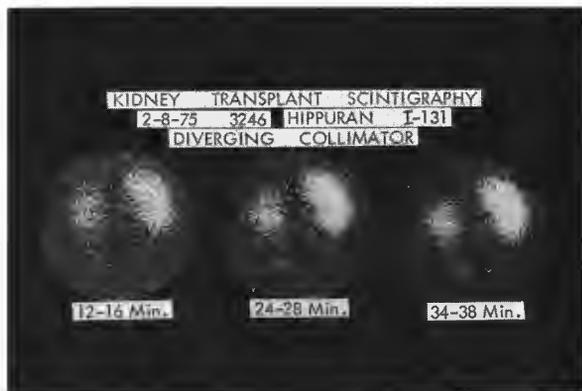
Selected scintigraphs obtained in a patient with two transplanted kidneys studied with ^{131}I -hippurate. Both kidneys are seen. The kidney on the patient's right (observer's left) was transplanted 15 months previously and is the site of severe chronic rejection. The other kidney was inserted one day previously and is not functioning because of acute tubular necrosis.
